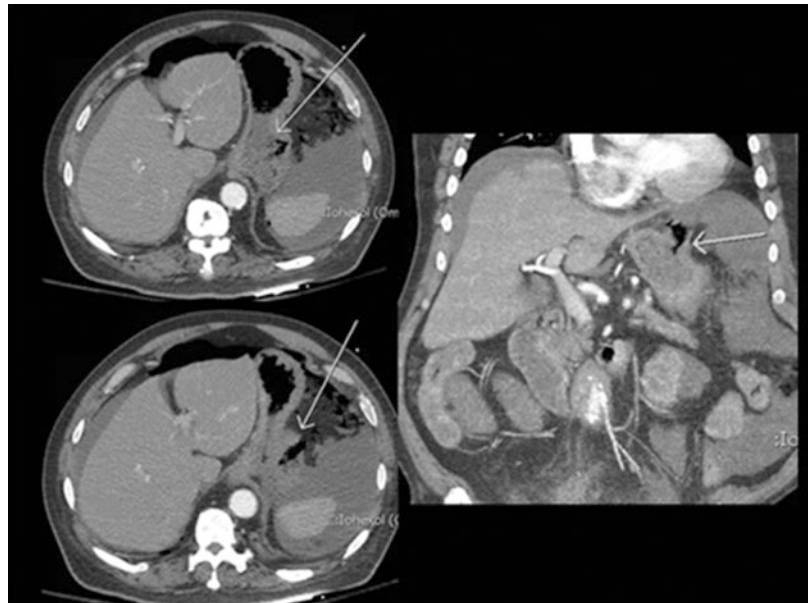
Axial and sagittal CT images showing a perforated gastric ulcer (arrows) with extravasation of intraluminal fluid and air
